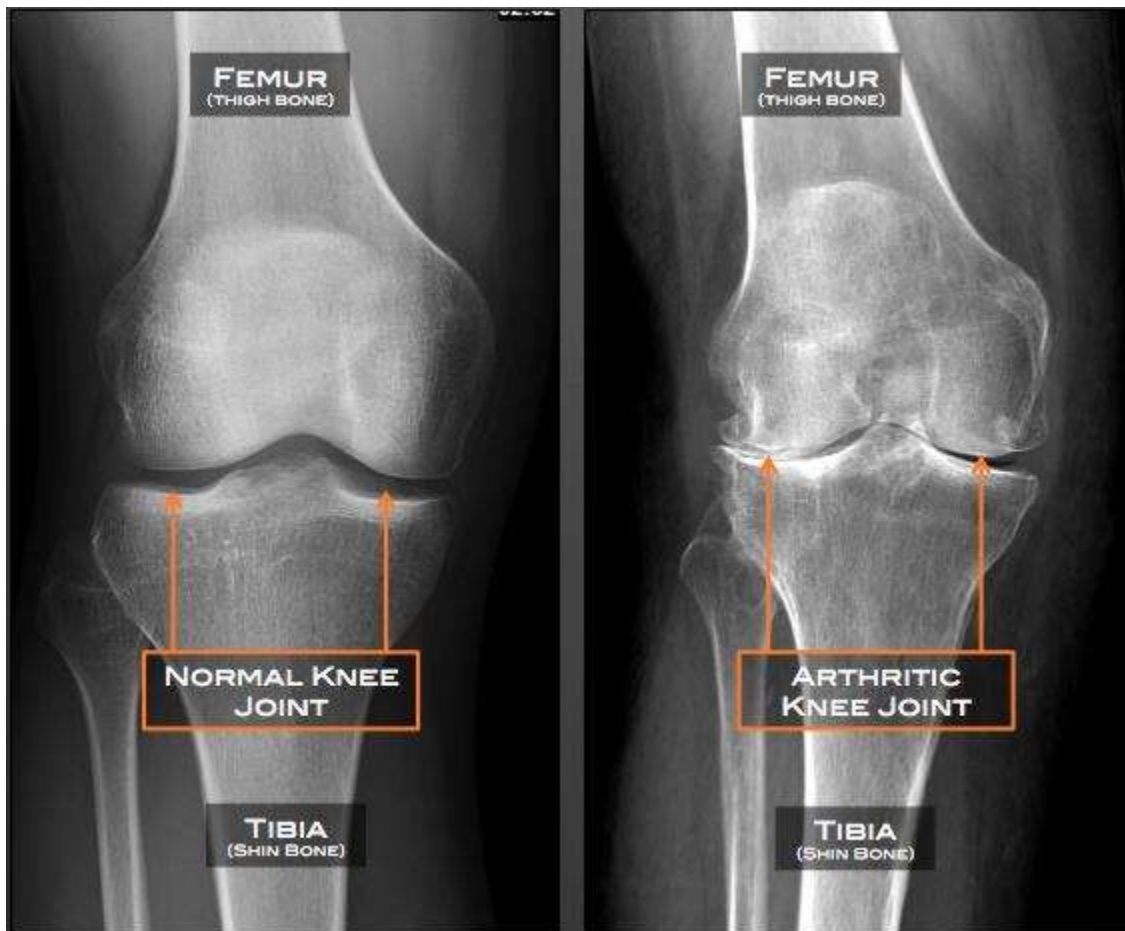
3 (X-ray knee joint)
